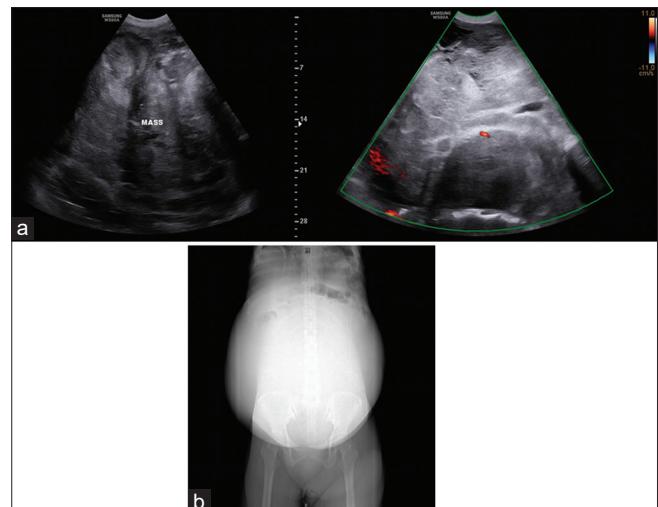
(a) Transvaginal ultrasound + Transabdominal ultrasound with doppler studies. Pelvic ultrasound revealed was a huge pelvoabdominal solid, thick walled mass measuring $42.0 \times 38.6 \times 34.0$ cm (Volume 2862 mL) which on color flow mapping showed minimal intratumoral flow (score of 2). On IOTA Adnex Model, the risk for malignancy is 99.4% (risk for borderline is 0.6%, risk for stage I ovarian cancer is 7.2%, risk stage II-IV ovarian cancer is 82.15 and risk metastatic cancer to adnexa is 9.5%) and the chance for benign tumor is 0.6%. (b) WAB CT Scan with triple contrast. Primary consideration is a neoplastic process, likely ovarian in origin: 1) dermoid cyst with aggressive features 2) cystadenocarcinoma, III to fairly defined hypodense hepatic lesions at segment 8, mild hydronephrosis, left, nephrolithiasis, right; Compression and contacting of the small and large bowels is noted. The mass appears to encircle the rectosigmoid area
